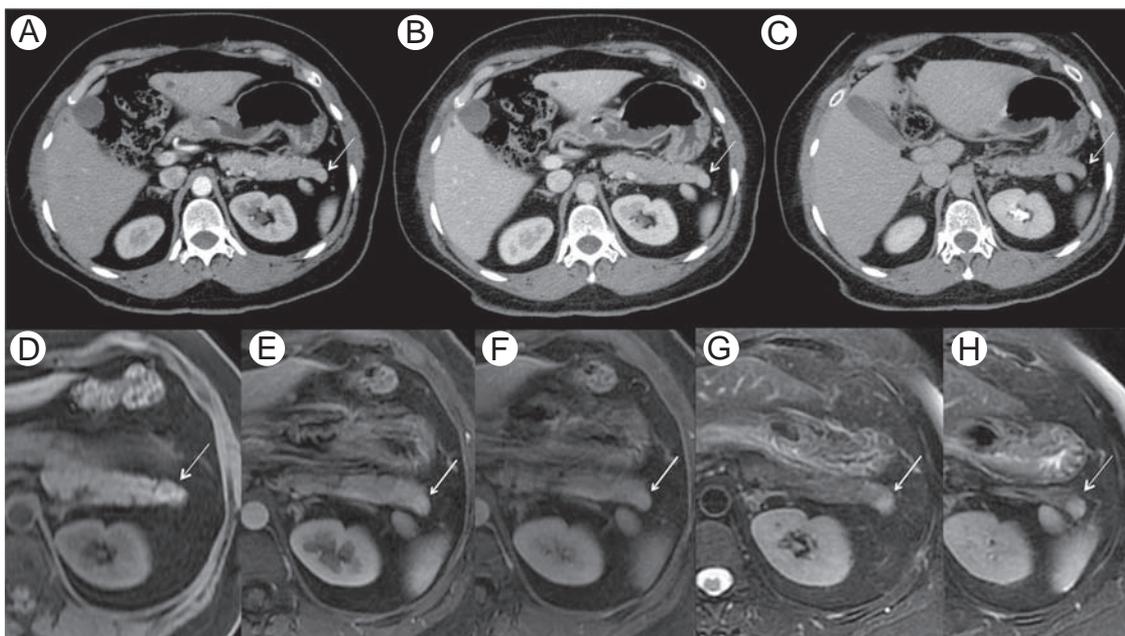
Intrapancreatic accessory spleen in a 40-year-old man with an incidental pancreatic mass. Arterial (A), portal (B), and delayed (C) CT images demonstrate a 1.5-cm pancreatic tail mass (arrows) that shows enhancement a little more pronounced than that of the normal pancreatic parenchyma, matching the density of the spleen on all phases. Unenhanced, arterial and portal phases of dynamic contrast-enhanced MRI (D-F) show the accessory spleen undergoing a pattern of enhancement that is similar to that of the spleen (arrows). Similarly, on axial fat-saturated T2-W images (G and H) the intrapancreatic accessory spleen (arrows) has a relative hyperintense signal similar to that of the spleen.
